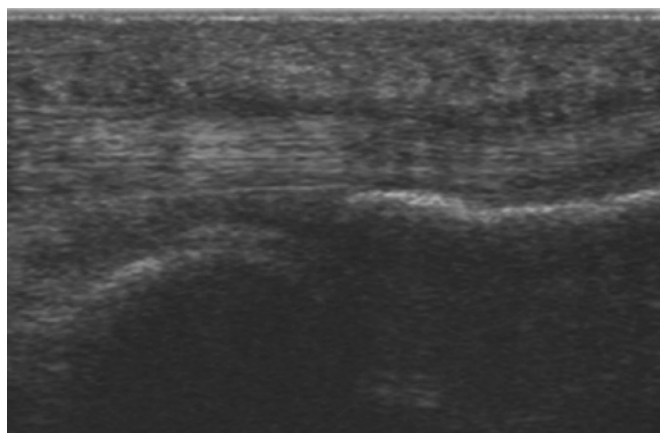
Ultrasound shows tenosynovitis of the third finger's flexor tendon at the proximal interphalangeal joint in the palmar longitudinal view.
